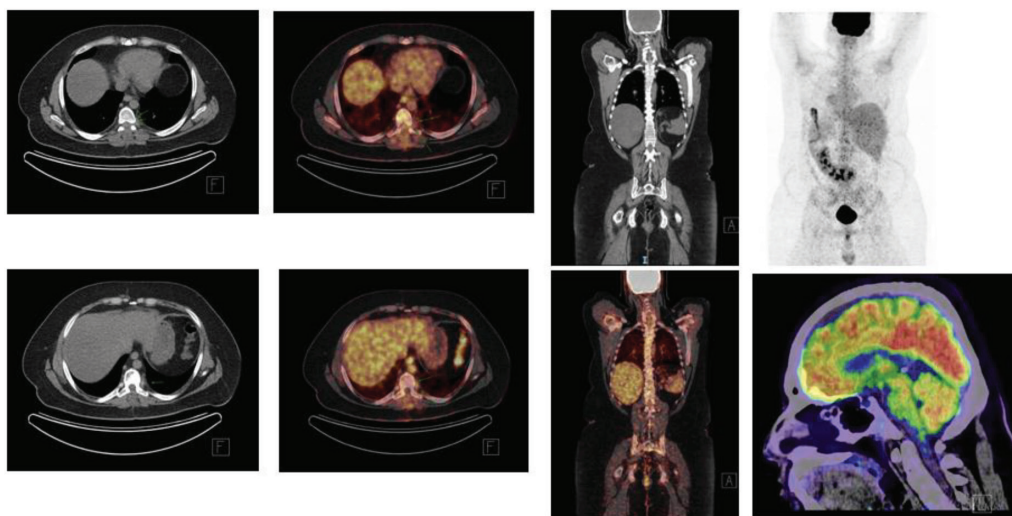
PET/CT scan study on 1 September 2020 showed no significant change of residual left paravertebral mass adjacent to T7, 8 vertebral bodies, 1 cm in diameter, SUVmax = 2.86 (previous 1 cm SUVmax=2.6, initially 1.8 cm thick, SUVmax= 15.9) which was determined as complete metabolic response, score II.
